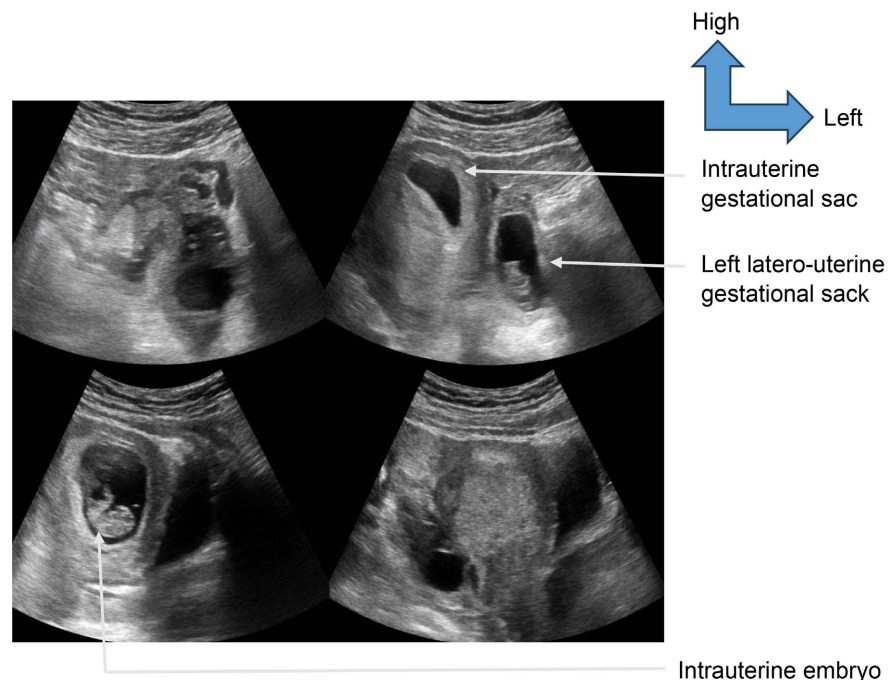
Ultrasound images of intrauterine and ectopic gestational sacs.
